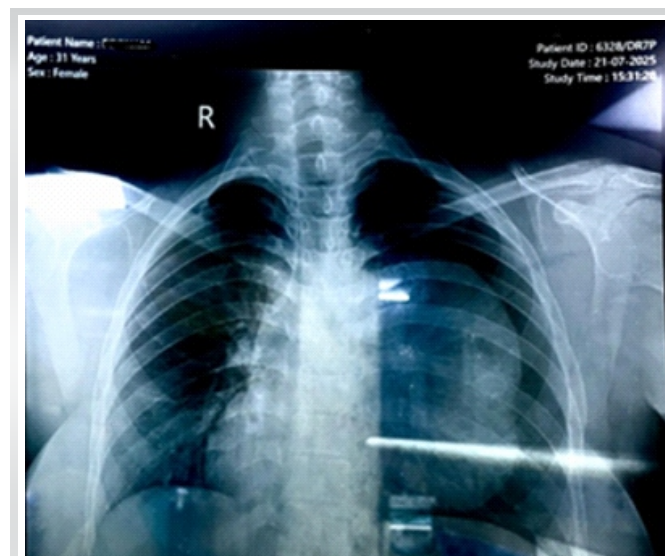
Preoperative chest radiograph showing a massive left-sided opacity with significant contralateral mediastinal shift, highlighting the risk of hemodynamic instability during induction.
